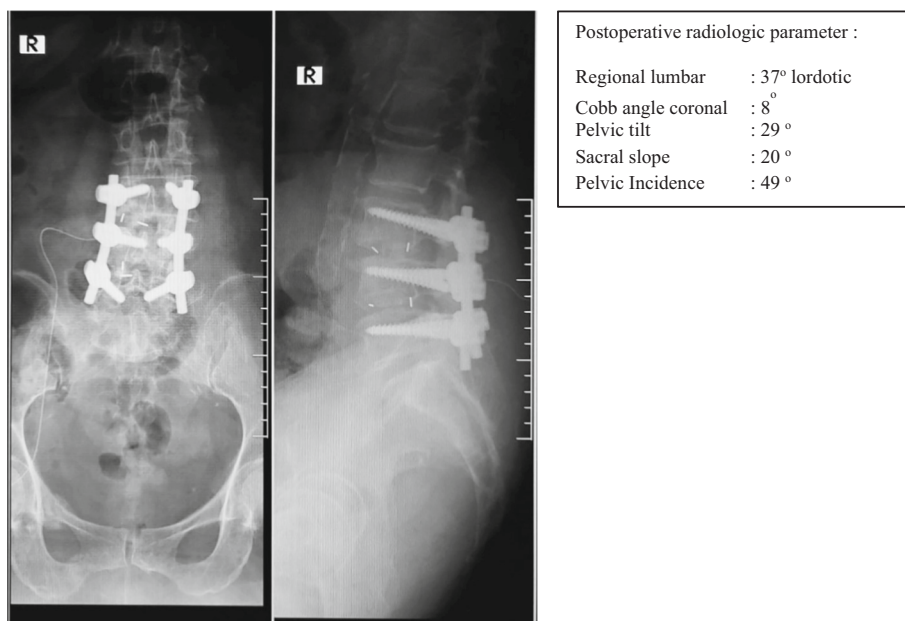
Case 1 postoperative radiograph.
